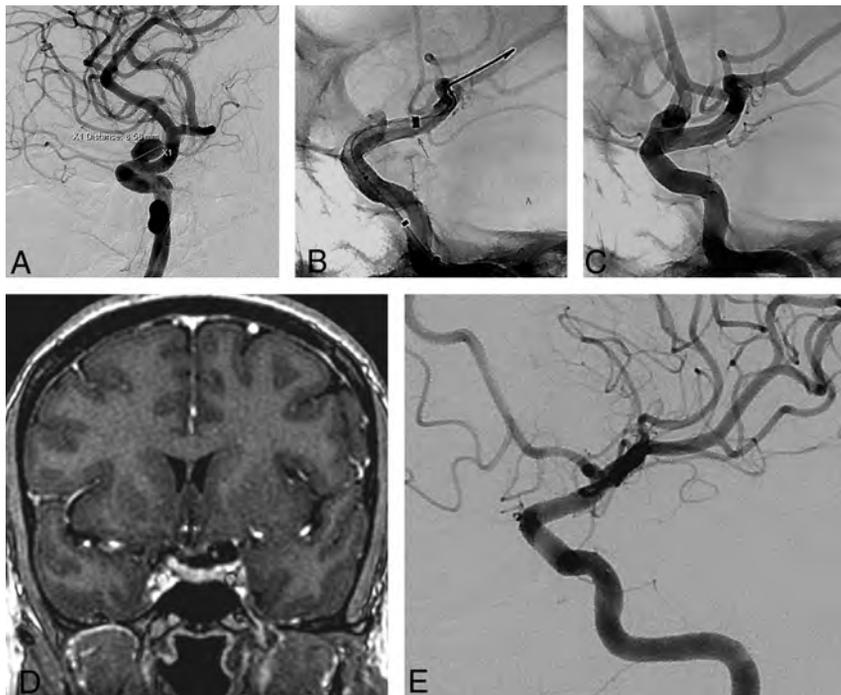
A, Left ICA angiogram shows a supraclinoid aneurysm similar to the aneurysm of the patient in Fig 1. B, Angiogram after deployment of the flow diverter shows malapposition at the distal end of the device (arrow). C, Angiogram at the end of the procedure shows good apposition of the device and a stent inside the device. D, Contrast-enhanced coronal MR image 3 months after the procedure shows no residual filling. E, Follow-up angiogram obtained 6 months after the procedure shows complete occlusion of the aneurysm.
